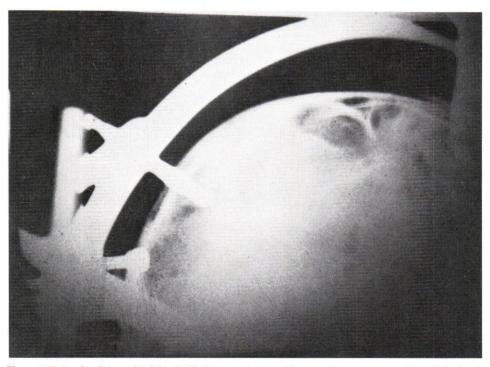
Lateral radiograph of the skull of a seventy year old man, showing penetration of a halo pin through the inner table of the skull.
